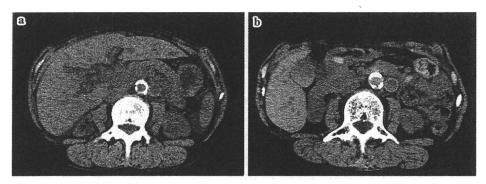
a: CT scan of the abdomen at the liver shows marked hepatomegaly. No obvious nodular lesions are depicted in the liver. b: CT at almost the same level taken one year previously shows a normal-sized liver.
